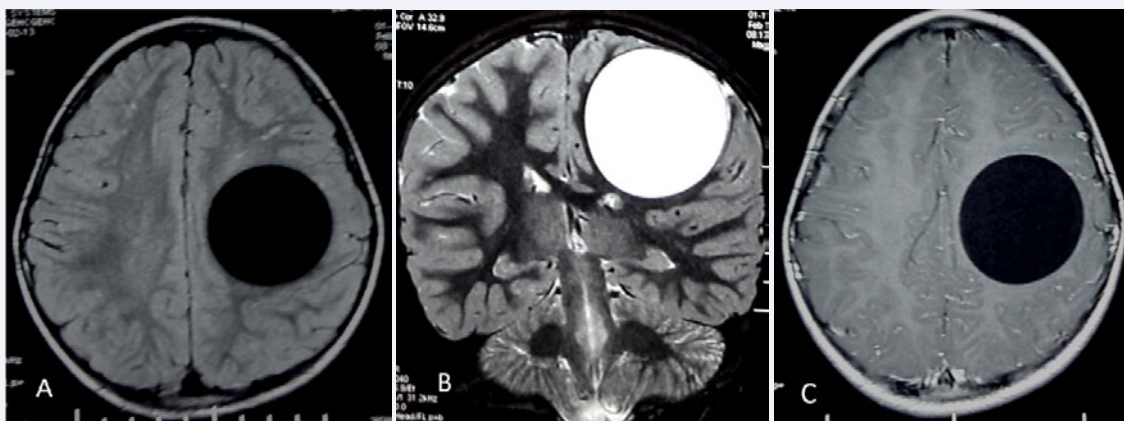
Cerebral MRI: FLAIR axial (A), T2 coronal (B) and T1 with contrast (C) images showing fronto parietal cyst compressing the frontal horn. The cyst is like cerebrospinal fluid and the cystic wall is hypo signal T2 suggestive of Hydatid cyst.
